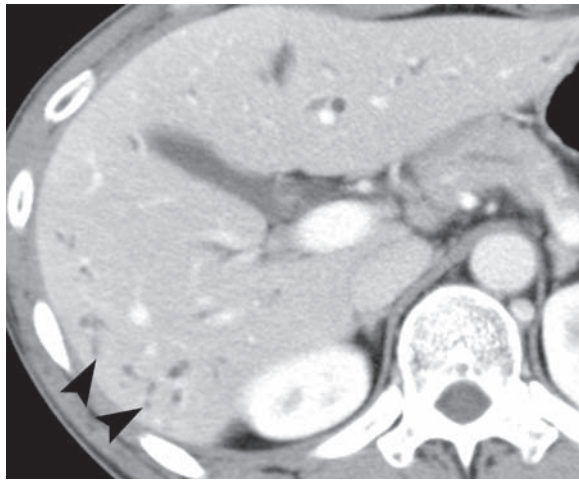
Clonorchiasis of the liver in a 39-year-old man. Contrast-enhanced CT scan shows dilatation of the peripheral intrahepatic bile duct (arrowheads) but no dilatation of the central duct.
